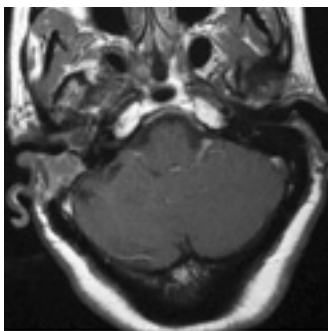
T1-weighted post-contrast MR image
